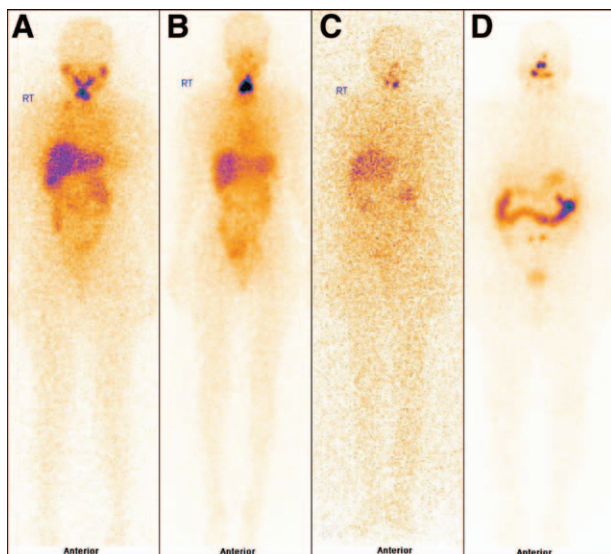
Whole body I-131 planar scintigraphy: anterior views showing examples of nil to trace nasal uptake (A), low uptake (B), moderate uptake (C), and high nasal uptake (D).
